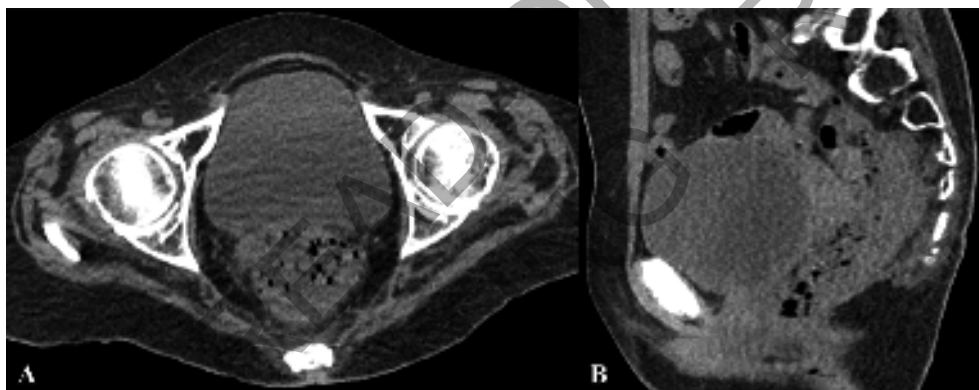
Axial CT (A) without contrast, with sagittal reconstruction (B), demonstrate the communication between the rectum and the vagina with the presence of faecal material in the vaginal lumen.
